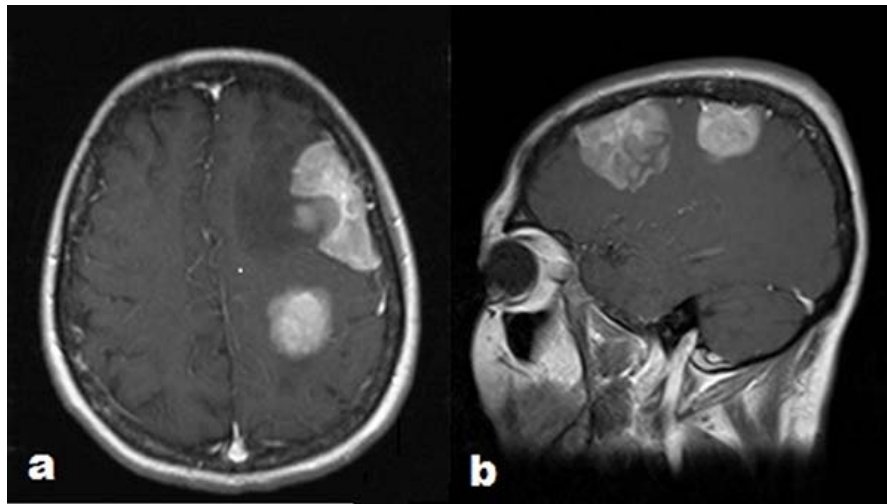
Axial (a), sagittal(b) gadolinium-enhanced T1-weighted MRI scans showing two larger extra axial hyperintense masses with peritumoural oedema and additionally, hypointense area on frontal hyperintense lesion.
